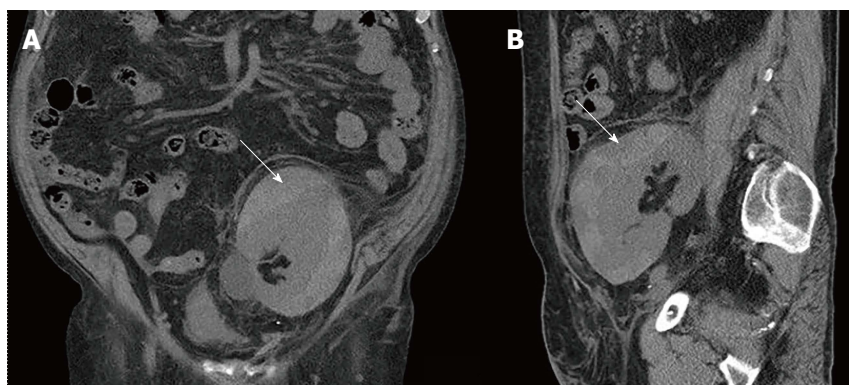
Computed tomography without intra-venous contrast of the transplanted kidney. A: Coronal view; B: Sagittal view. A subscapular hematoma 12 cm × 2.5 cm in size was compressing the transplanted kidney (arrows).
